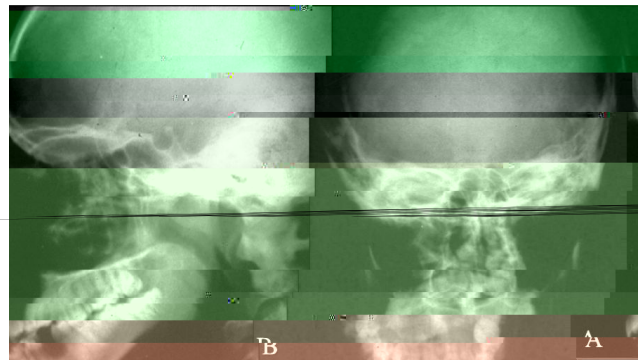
Lateral (A) and forward (B) radiographs post-surgical. Note the absence of the projectile.
